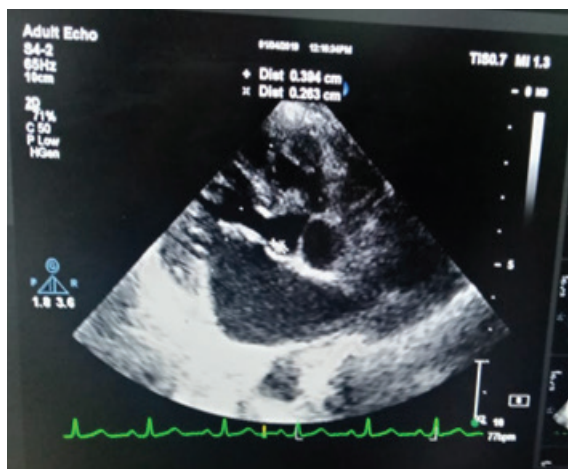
Echocardiography Showed Vegetation at NCC of the Aorta
